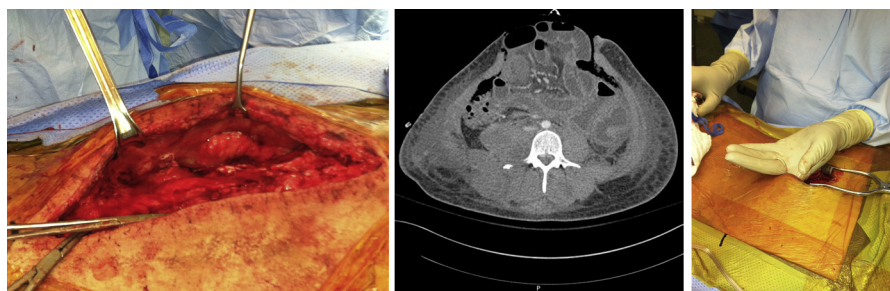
Case 1: (Left) Right-sided Morel lesion with separation of the subcutaneous tissue from the underlying muscular fascia. (Middle) Axial computed tomography at L4 showing a fluid collection (Morel-Lavallée lesion) just deep to subcutaneous layer posteriorly. (Right) Right-sided Morel lesion with separation of the subcutaneous tissue from the underlying muscular fascia.
